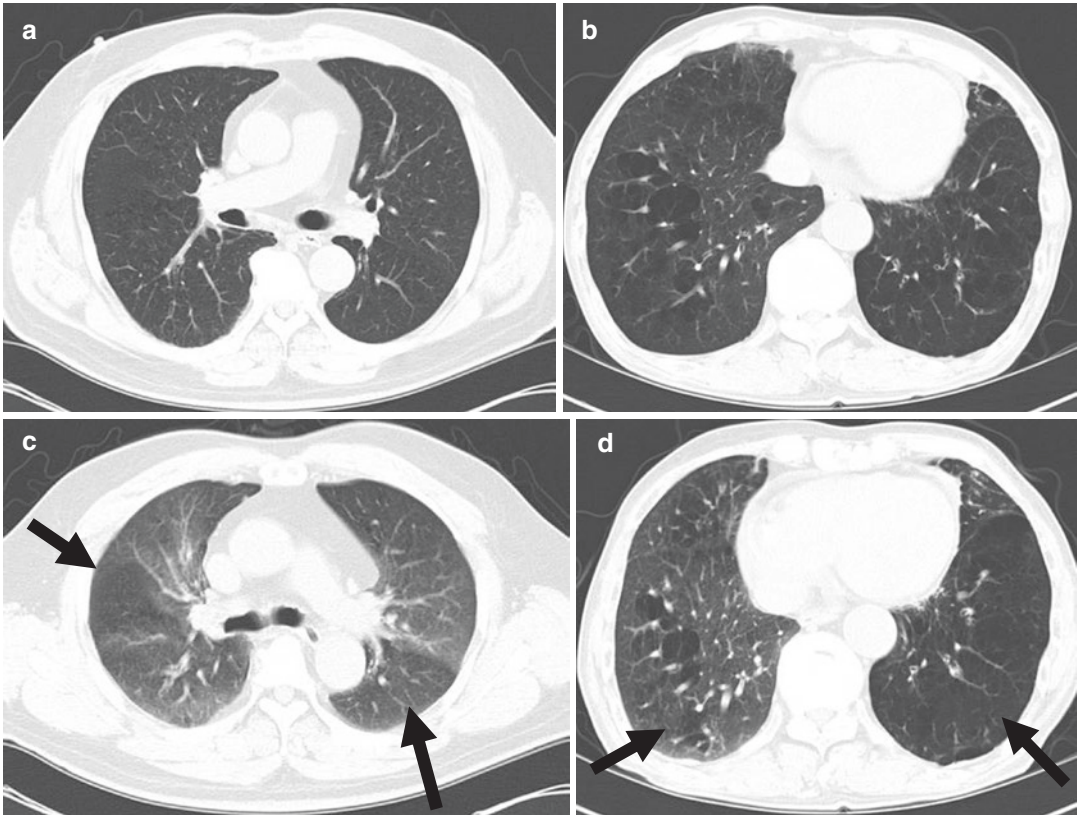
Air trapping assessment using inspiration- and expiration CT images. Air trapping should be assessed by side-by-side comparison of inspiration (a, b) and expiration (c, d) CT images. Expiratory air trapping can be
